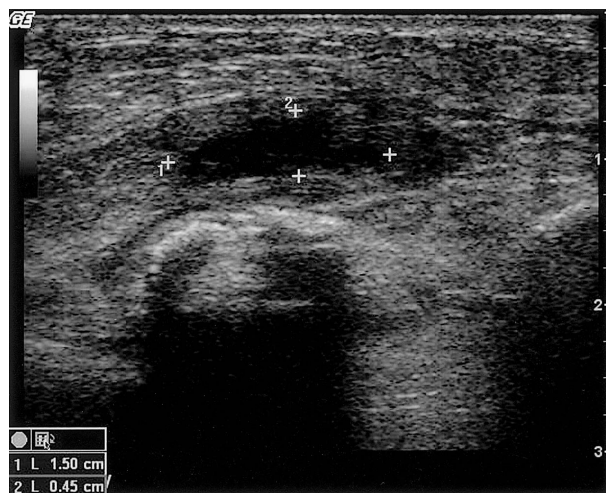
A 1.5×0.45 -cm hypoechoic lesion is noted at the left chest wall on ultrasonography.
